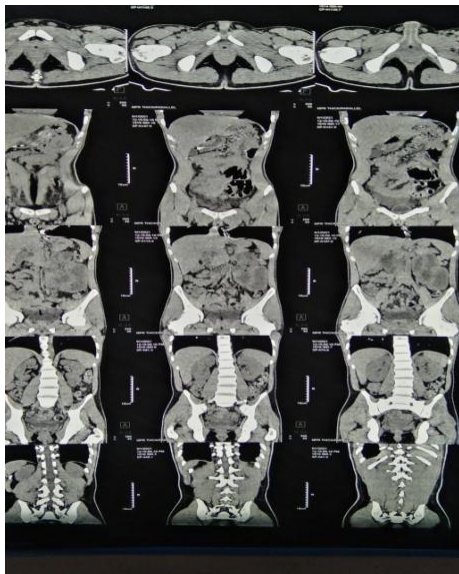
CT Scan showing the proximal jejunojenunal intussusception
